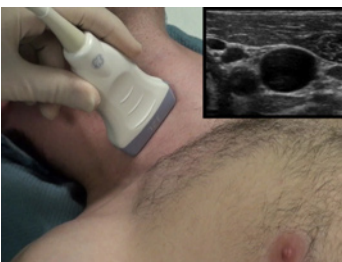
Ultrasound Transducer and Resulting Image.
